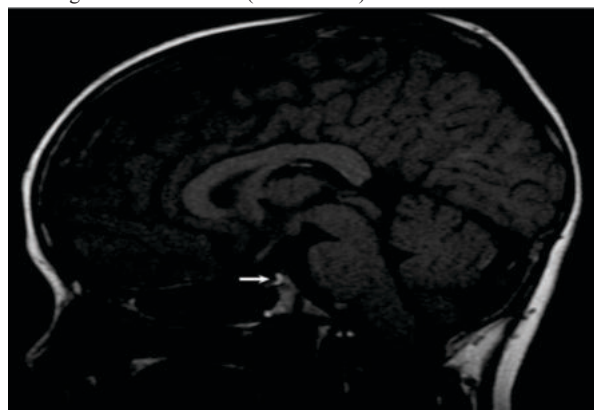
Sagittal T1 weighted Magnetic resonance imaging in a 1-year-old boy with multiple pituitary hormone deficiency (MPHD) showing a small anterior pituitary with bright spot of the posterior pituitary in a normal position
